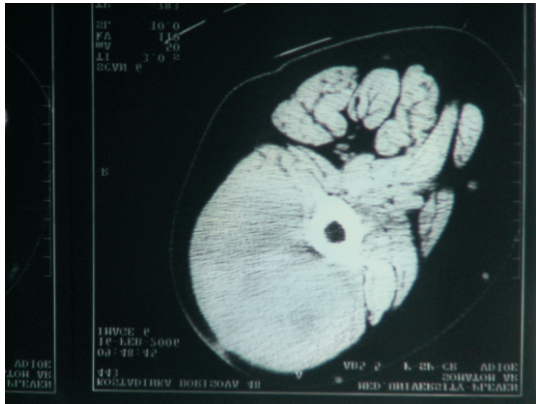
CT finding – presence of tumor formations, located intramurally in vastus lateralis muscle and vastus intermedius, and a lytic lesion in the zone of the femoral cortex.
